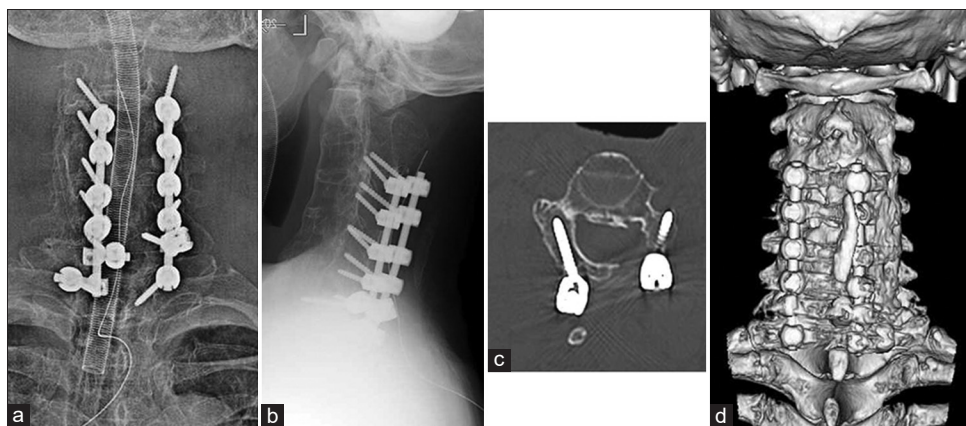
Postoperative X-ray image. (a) Frontal view. (b) Lateral view. (c) Computed tomography axial view. (d) Three-dimensional computed tomography
